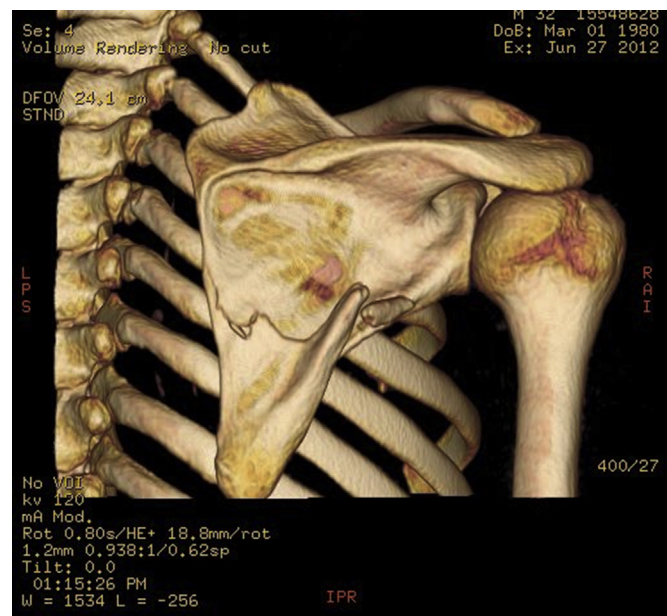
Three-dimensional colored CT image of the patient's right shoulder.
